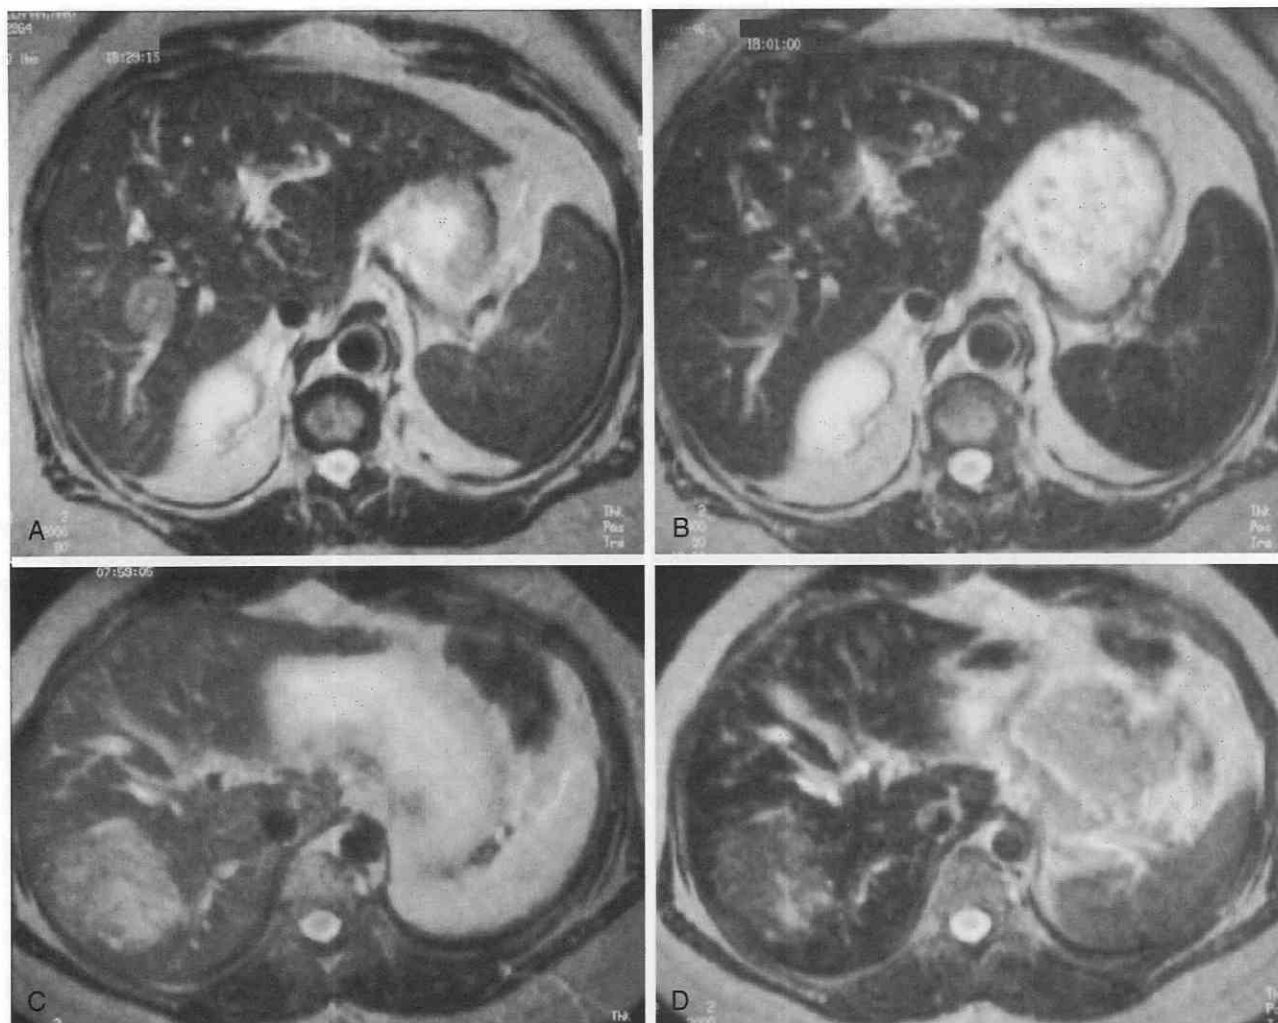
Focal nodular hyperplasia. *A*, Unenhanced T1-weighted image demonstrates a 2-cm lesion in the right hepatic lobe. *B*, T2-weighted image after superparamagnetic iron oxide (SPIO) enhancement demonstrates signal loss of the lesion. *C*, Signal loss is seen in a different patient between unenhanced T2-weighted images. *D*, SPIO-enhanced imaging.
